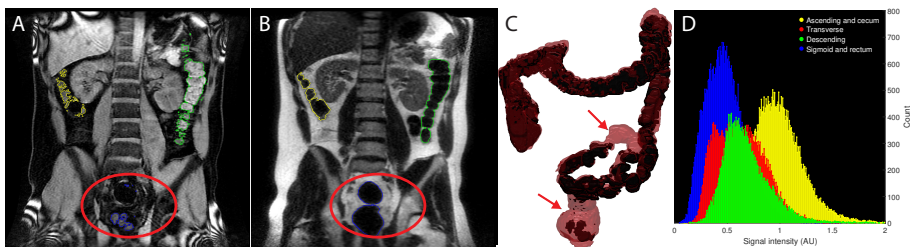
Analysis of colonic content. A) LAVA-Flex image showing area in the rectosigmoid colon with luminal gas. B) T2-weighted image showing area in the rectosigmoid colon with luminal gas. C) 3D-model of the segmented colonic volume and content. Arrows point to luminal gas. D) Histogram representation of segmented colonic content on T2-weighted images in one dataset. High values indicate more water content, where ascending colon content contain most water (yellow) and rectosigmoid colon contains least water (blue).
